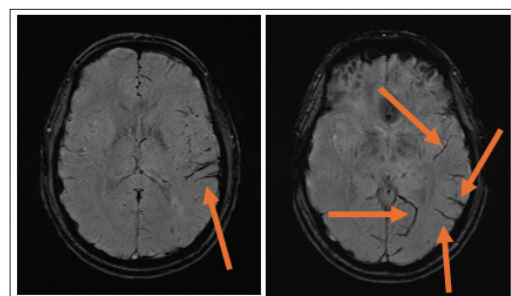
Axial Susceptibility-Weighted MRI of the Patient's Brain
